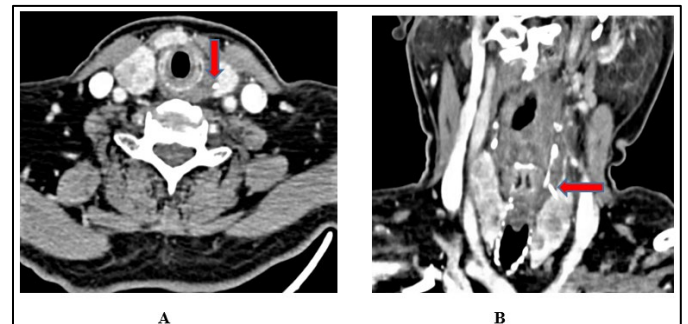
CT neck revealed a linear hyperdense FB (2.3 cm) in length seen piercing through the left wall of upper cervical oesophagus and extended inferolaterally with its tip in the left thyroid lobe as visualized in axial (A) and coronal view (B).
